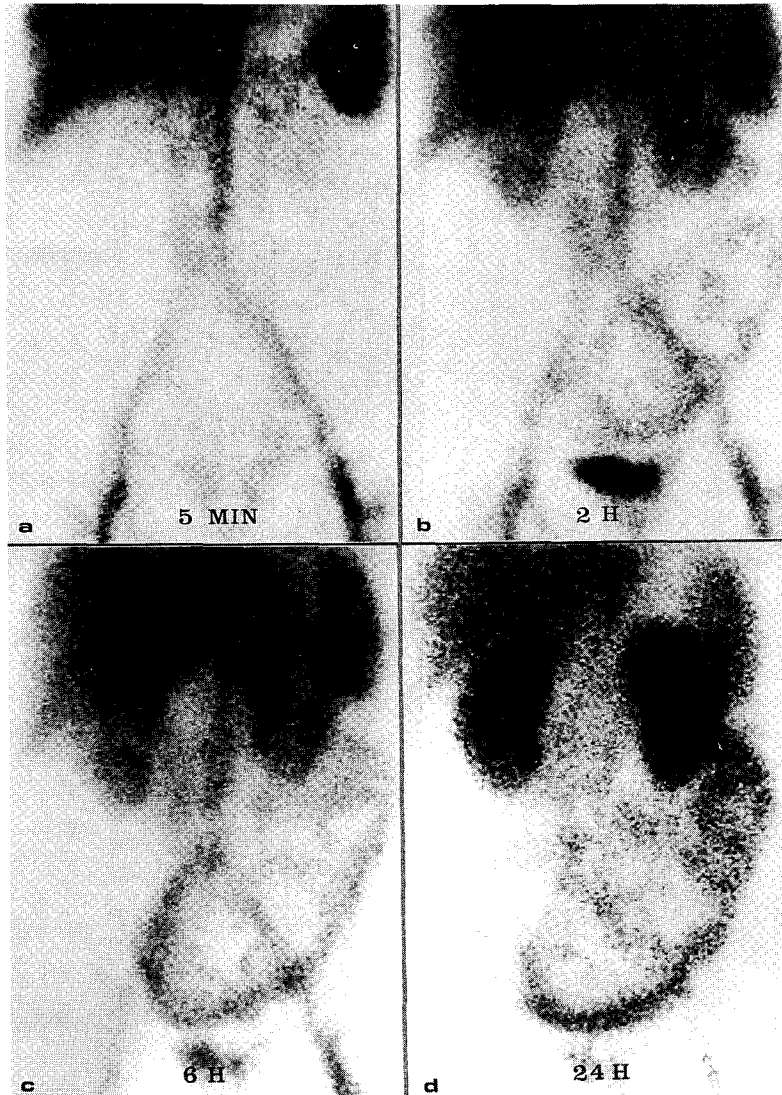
(a-d). Positive scintigraphy. Definite intestinal activity is noted in the lower abdomen from 2 hours after injection of ^{99m}Tc -HSA. The stomach does not show significant tracer uptake.
